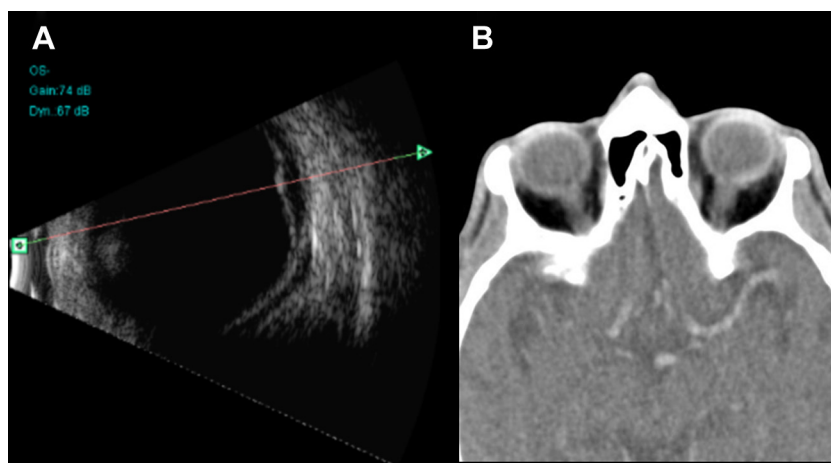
Ancillary tests. A: B-scan of the choroidal lesion with low internal acoustic reflectivity and no retinal detachment. B: CT scan of the head and orbits confirmed a choroidal thickening of 3 mm with contrast uptake.
